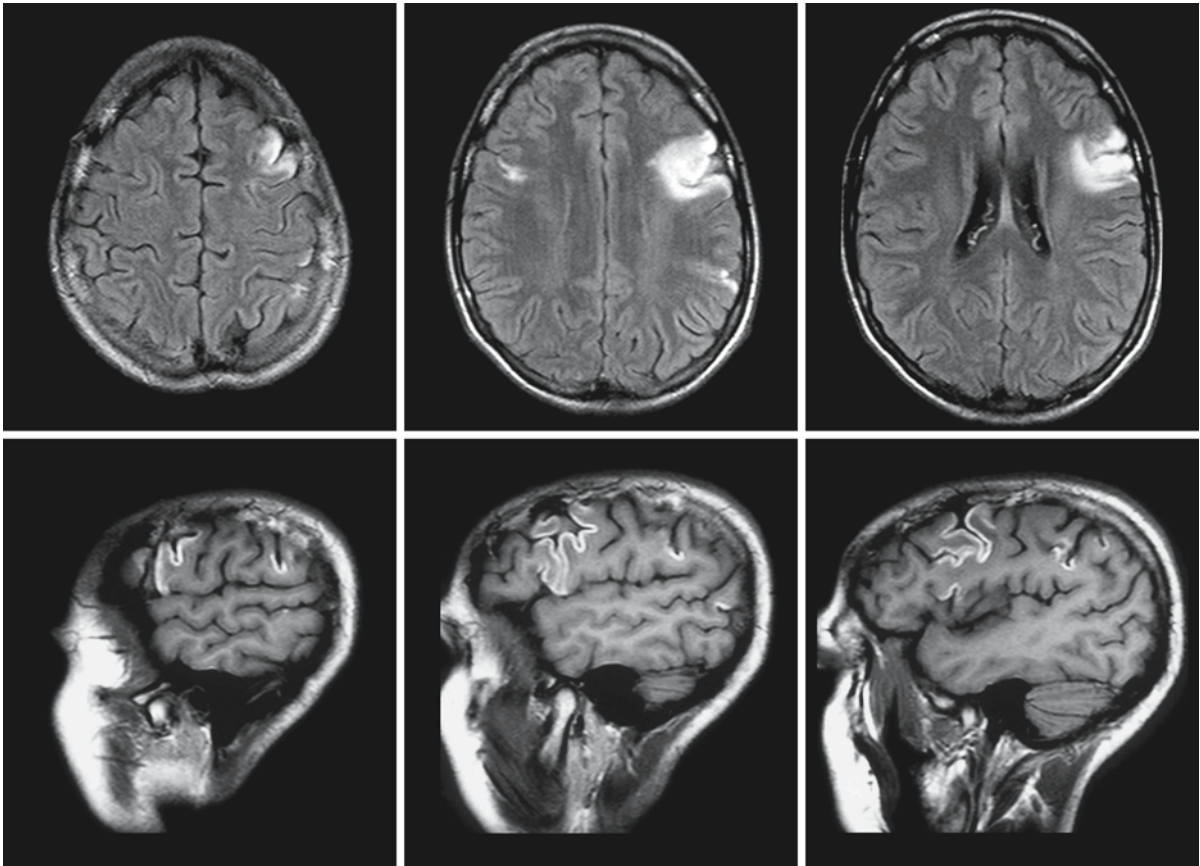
Transverse FLAIR (*first row*) and sagittal contrast enhanced T₁-weighted images (*second row*) of a 17-year-old girl who had been administered GABA and subsequently
